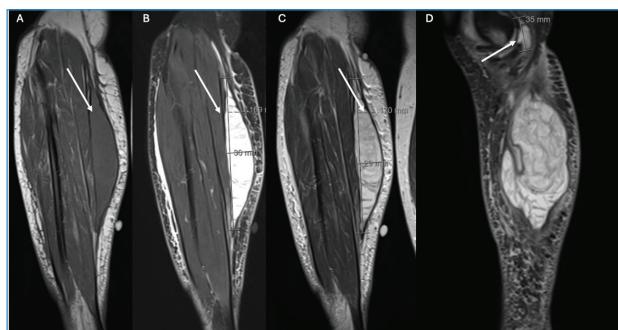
Coronal T1-weighted (A), T2- weighted (B and C) of right leg revealing a large well defined elongated lesion (white arrow) on the medial and posterior side of the right leg, between the medial gastrocnemius and the superficial fascia, with hyperintense signals not suppressed by fat suppression, compatible with a Morel-Lavallée lesion. It is additionally shown a Baker's cyst (D, white arrow) without indirect signs of rupture.
